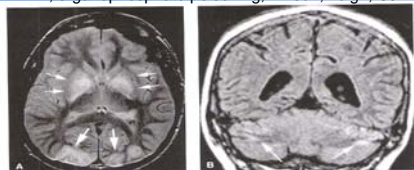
Carbon monoxide poisoning. A: Axial SE 2800/90 image shows T2 prolongation in bilateral globus pallidus (small white arrows) and occipital cortex (large white arrows). B: Coronal FLAIR image shows some hyperintensity (arrow) of the cerebellar cortex.
